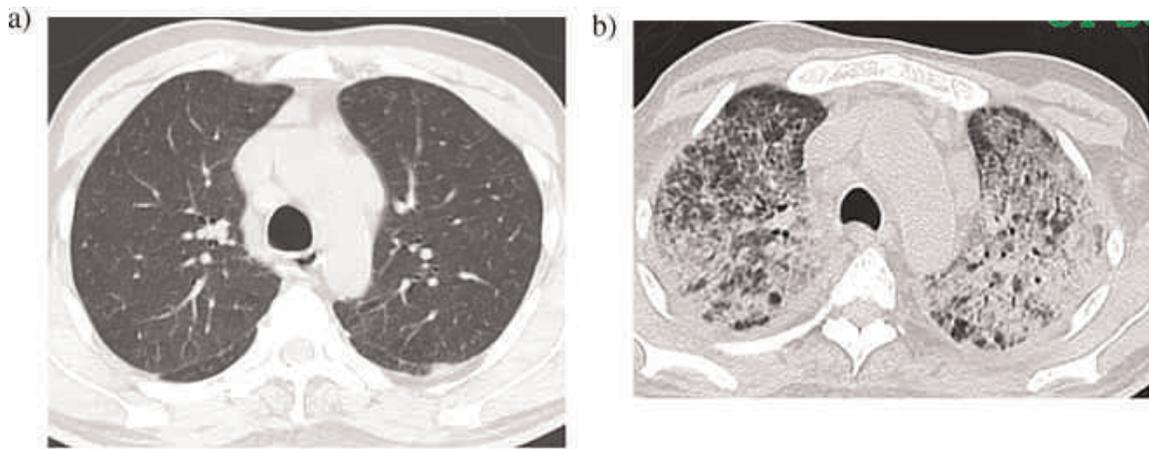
(a) Axial sections of CT thorax showing clear lung fields (b) showing dense consolidation.
